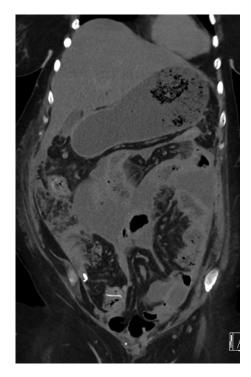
Patient had a slow recovery 6 weeks post cystectomy and presented with abdominal distension. CT showed diffuse peritoneal disease within the abdomen. Interestingly there was no evidence of peritoneal metastases on pre-operative imaging or at original surgery.
